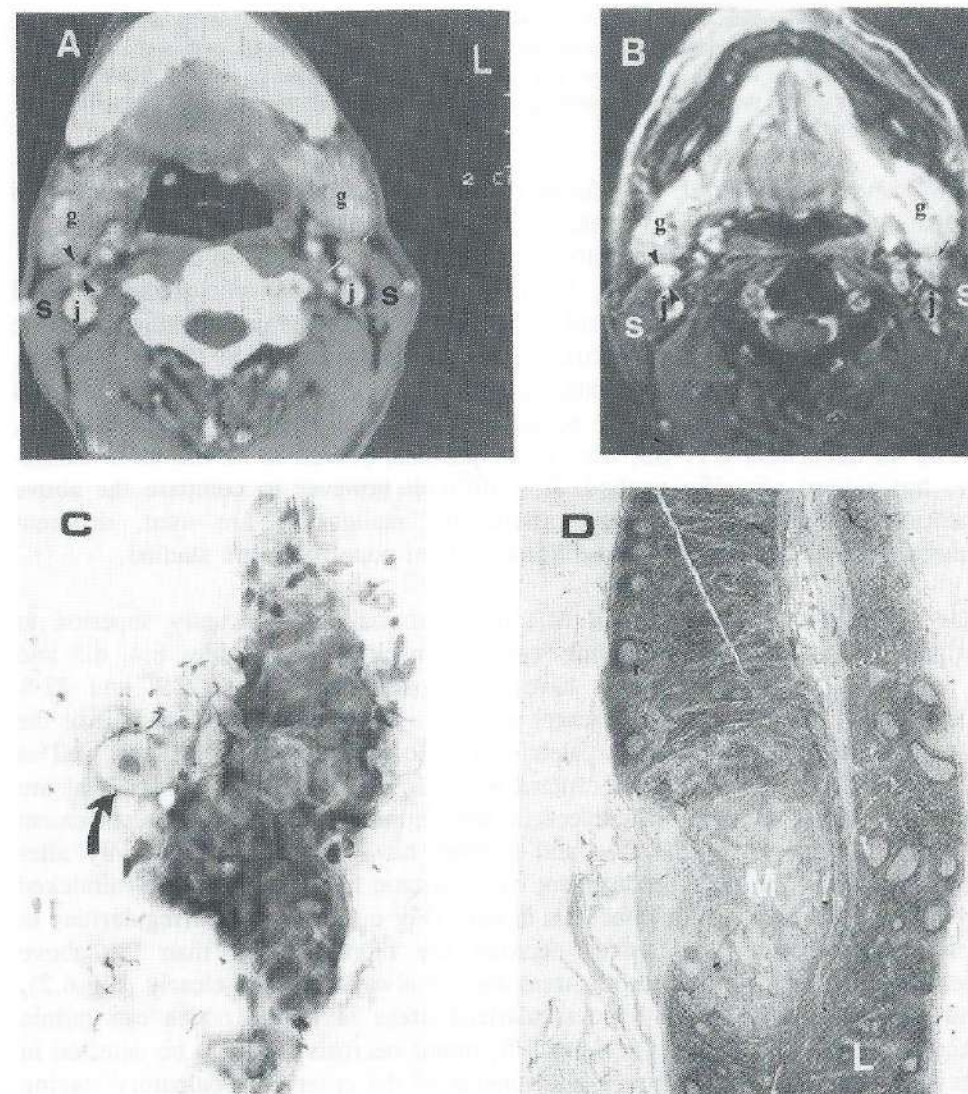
A. Contrast enhanced CT scan in a 52 years old man with a T2N0 floor of mouth carcinoma, treated with a commando resection and a comprehensive neck dissection of the left side. At the right subdigastic level a 5 mm node (arrowheads), and at the left side a 7 mm node (arrows) are depicted. Both nodes are located in front of the internal jugular vein (j), just medial and anterior to the sternocleidomastoid muscle (s), behind the submandibular gland (g). Although the node on the left was depicted with very small non-enhancing spots, it was erroneously classified as non-metastatic. B. Gd-DTPA enhanced gradient echo MR image at the same level. The node is now much more clearly depicted with irregular enhancement, and was classified as metastatic. The node on the right is
